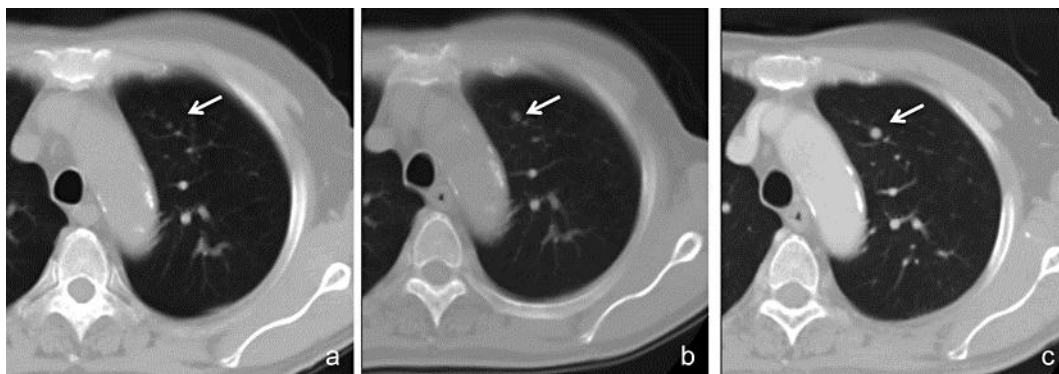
Chest CT revealing a pulmonary nodule (white arrows) before surgery (a). In subsequent CT scans taken after 1 year (b) and 2 years (c), the nodule slightly increased in size.
